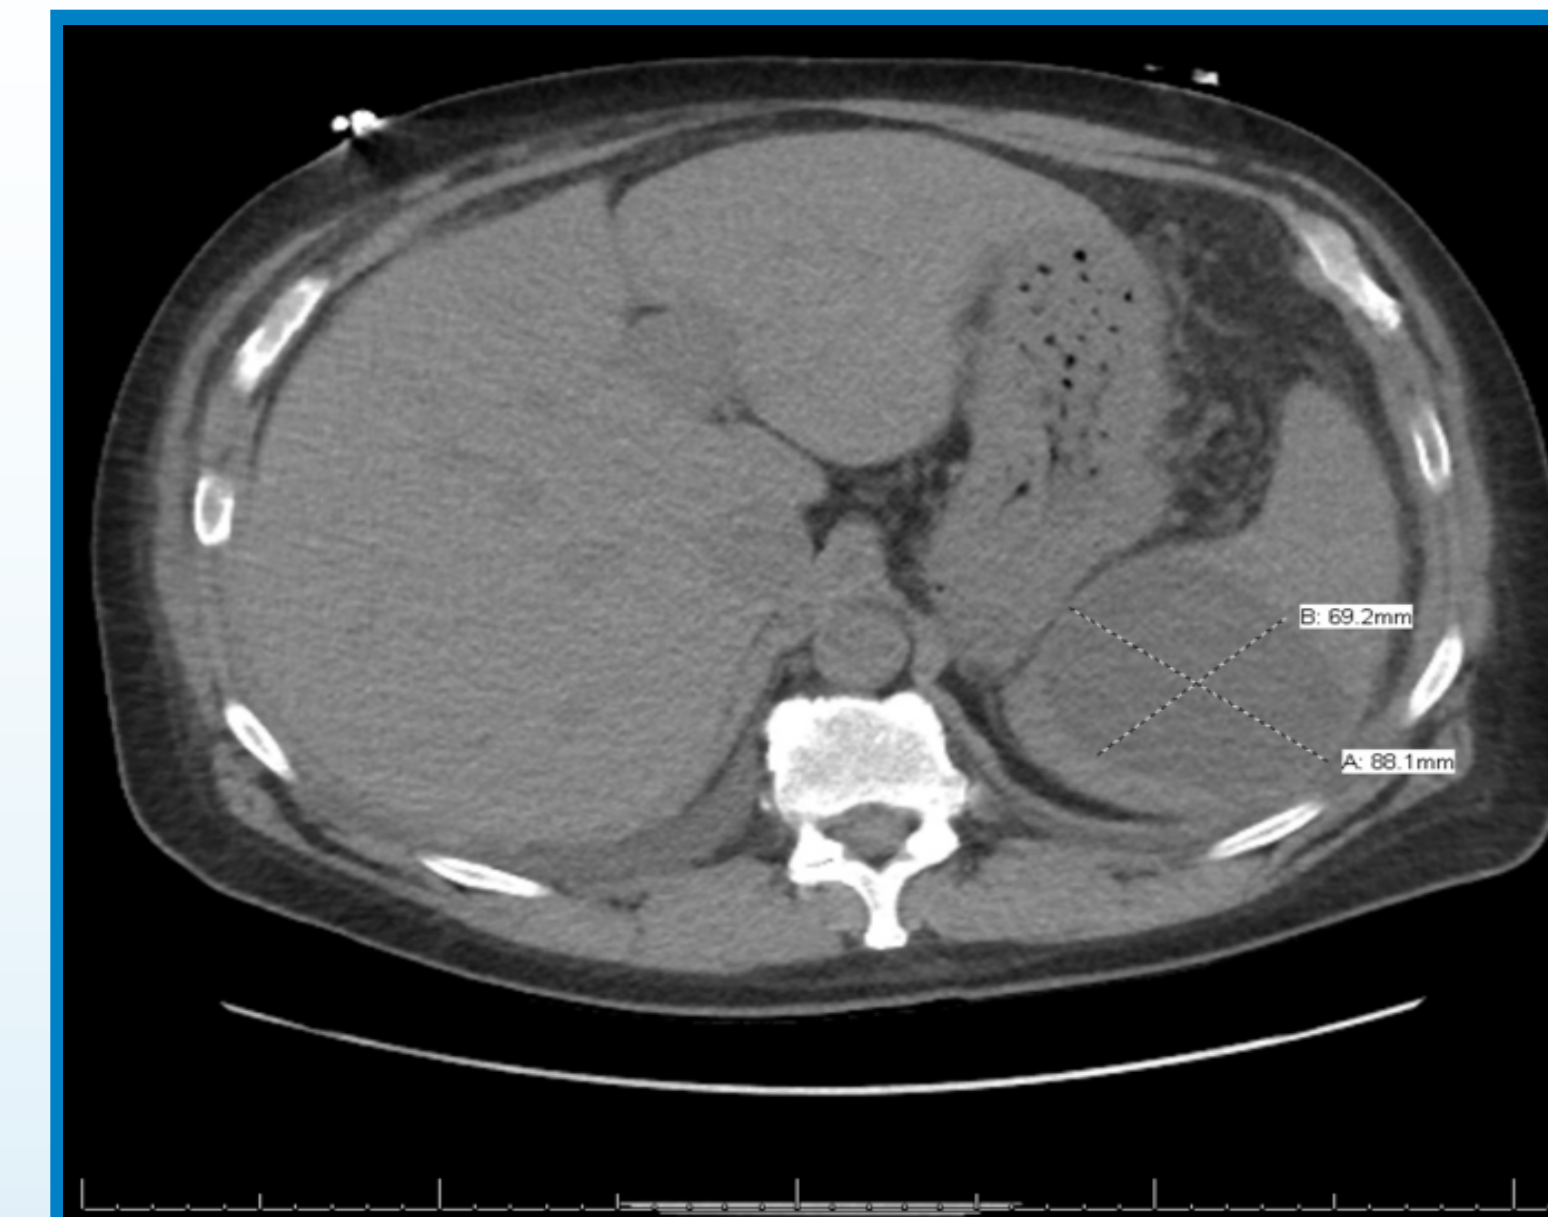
Splenic mass measuring 7.8 x 8.8 x 6.9 cm, similar in size to the results found on ultrasound examination.
